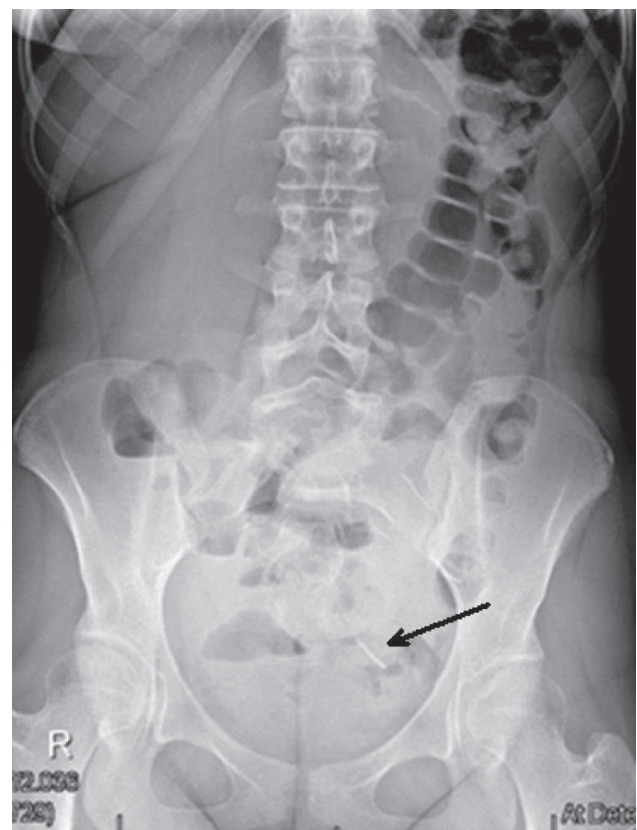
Postoperative abdominal x-ray revealed a V-shaped radiopaque object in the minor pelvis.
